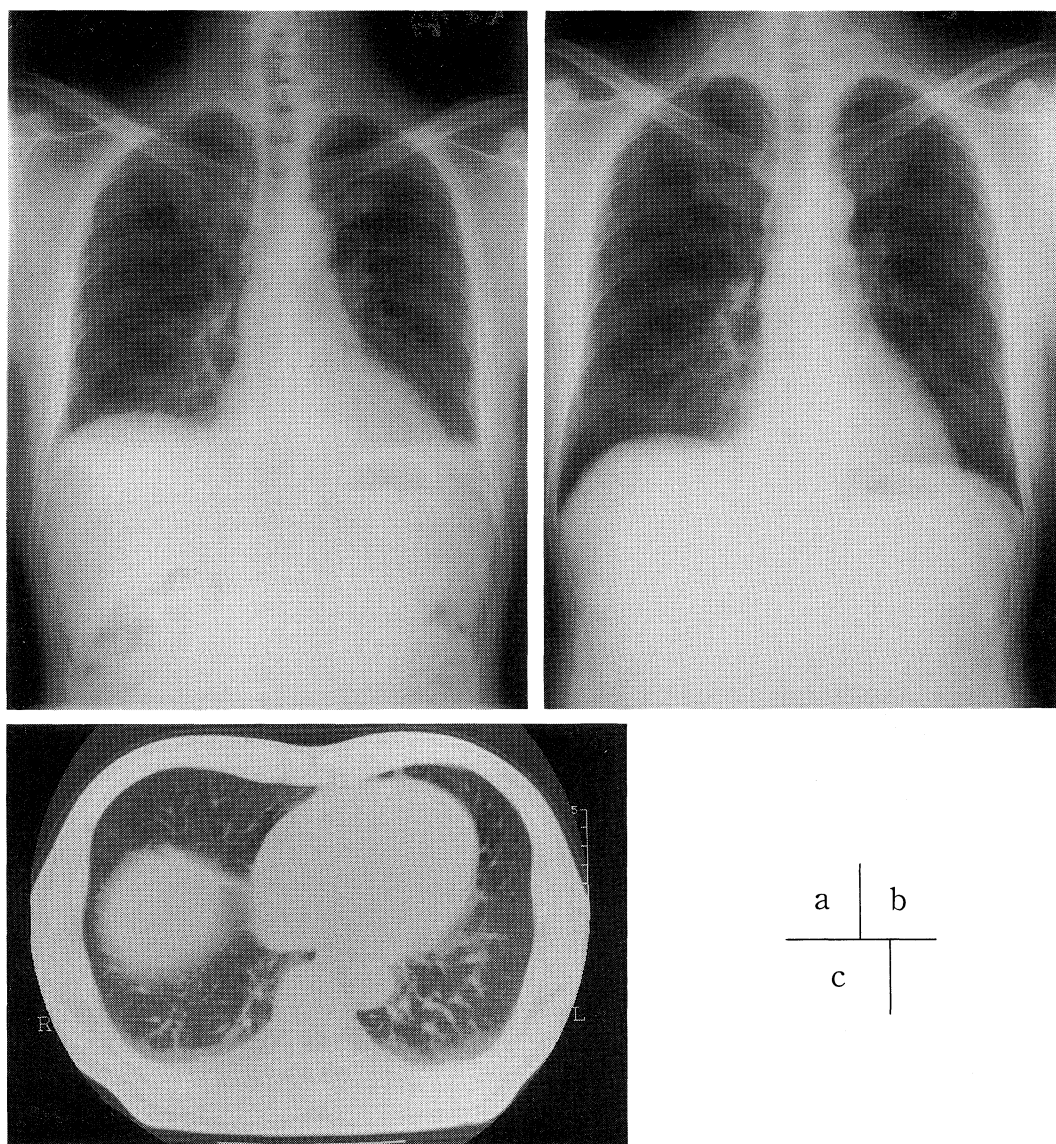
Chest roentgenogram (a) and chest CT on admission (c) revealed an interstitial shadow. Chest roentgenogram 2 days after admission (b), abnormal shadow was nearly diminished.
